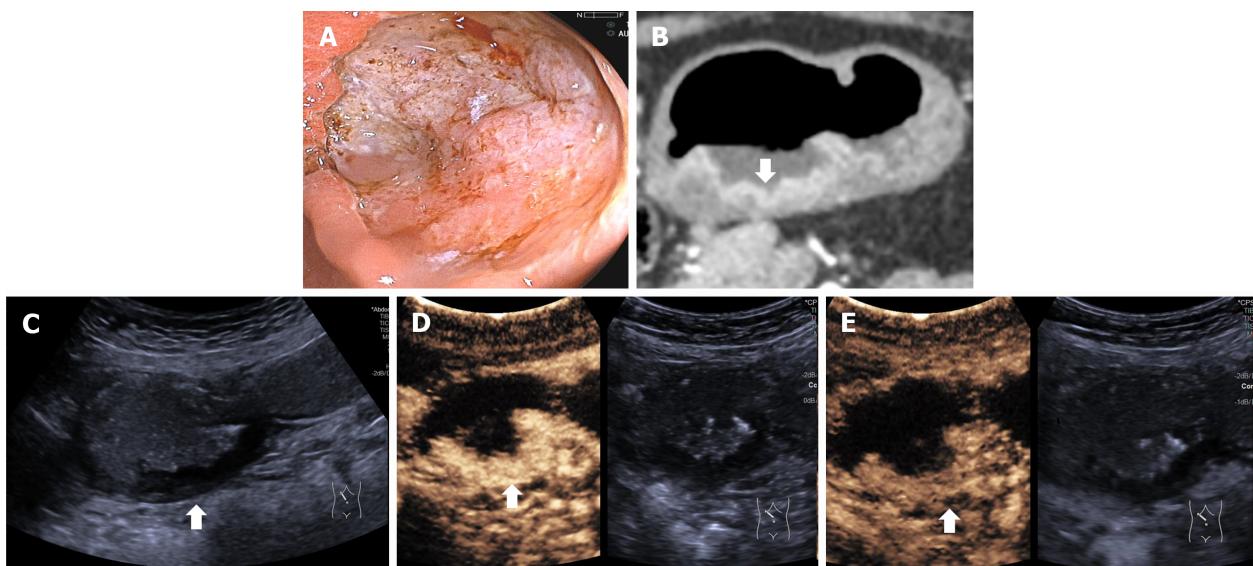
Images of T2 gastric cancer in a 65-year-old woman. A: Gastroscopic image shows a typical ulcerative tumor; B: Multi-detector computed tomography image shows transmural, enhancing tumor (arrow) with smooth outer border of gastric wall; C: ultrasonography image shows the hypoechoic ulceroinfiltrative tumor (arrow). The mucosa, submucosa and partly muscularis propria are disruptive; D: In the arterial phase, disruption of the mucosa, submucosa and partly muscularis propria are visualized. The lesion shows homogenous hyper-enhancement, similar to the normal submucosal layer; E: In the venous phase, the lesion shows homogenous hypo-enhancement. The hyper-enhancement strip of submucosal layer and partly hypo-enhancement strip of the muscularis propria are disruptive.
